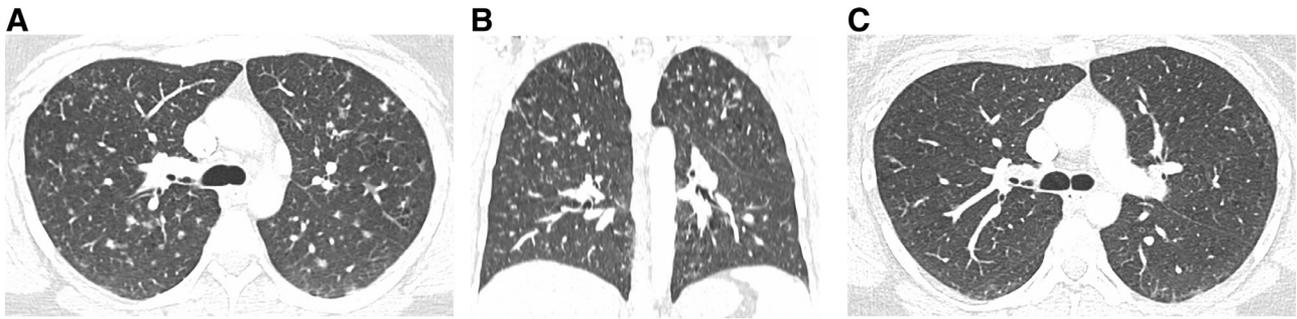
A 38-year-old female smoker with pulmonary Langerhans cell histiocytosis. Axial (A) and coronal reformatted (B) CT images show upper lobe predominant stellate nodules (arrows) and mild centrilobular emphysema. CT image 9 months after smoking cessation (C) shows resolution of the nodules.
